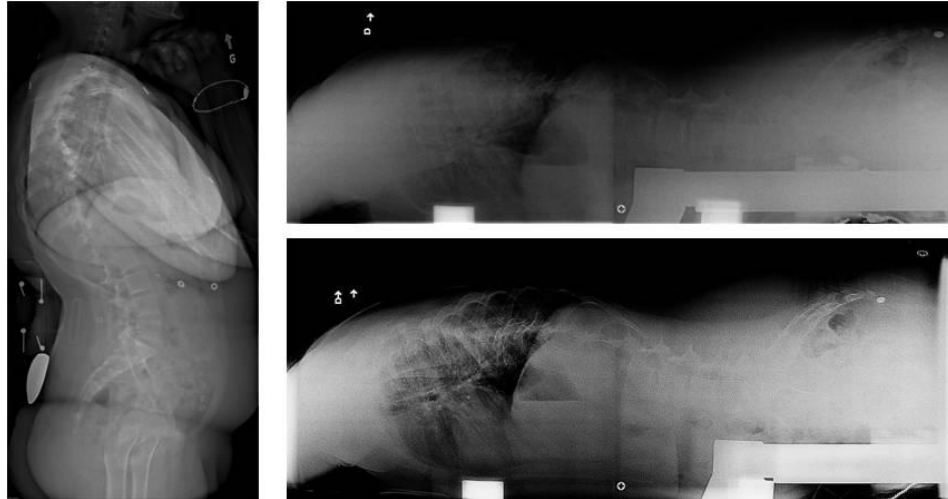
Lateral radiographs of scoliotic patient in the standing position (left), maximum disc space (top right) and maximum sagittal balance and standing sagittal curves (bottom right)
